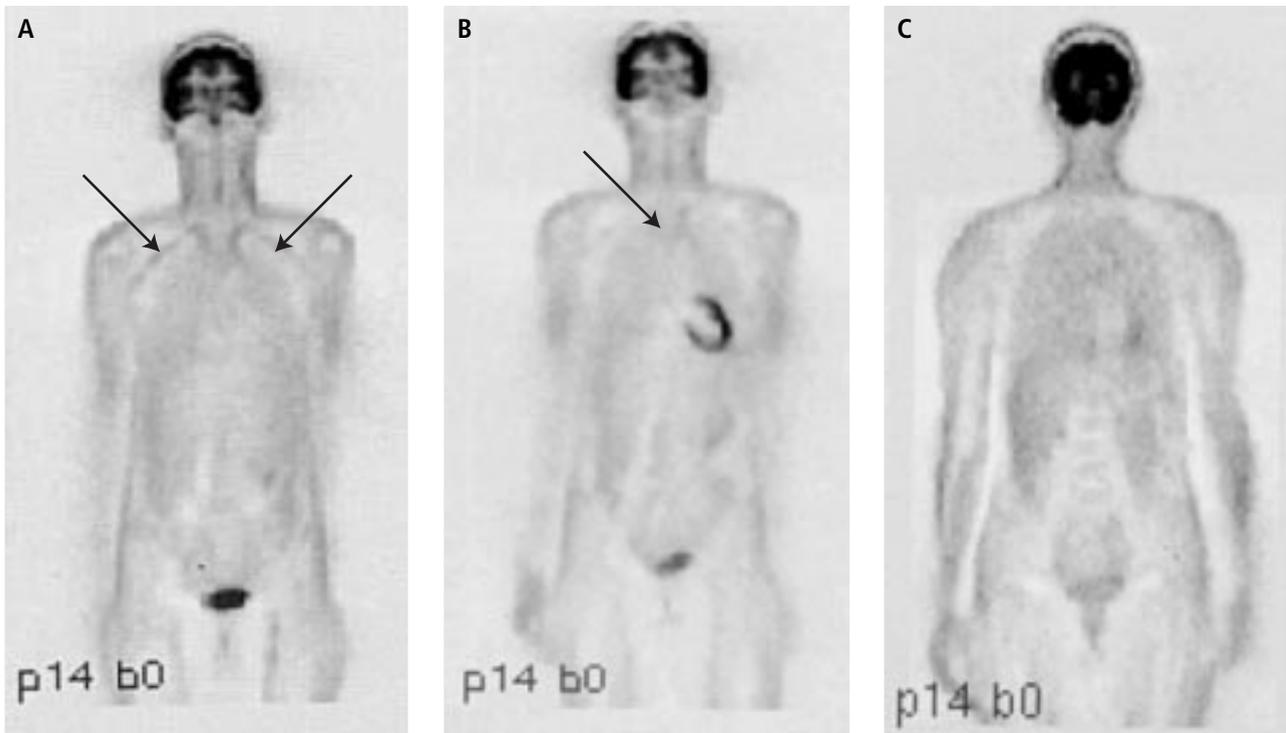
(A) Increased FDG-uptake at both subclavian arteries (arrows) in a patient with GCA, before therapy with steroids was started. (B) Same patient, 3 months later during steroid treatment (methylprednisolone 16 mg/day). Almost complete disappearance of vascular FDG-uptake (arrow). (C) Same patient, at six months of steroid therapy (methylprednisolone, 8 mg/day). There is no FDG uptake visible any more at the large thoracic arteries.
